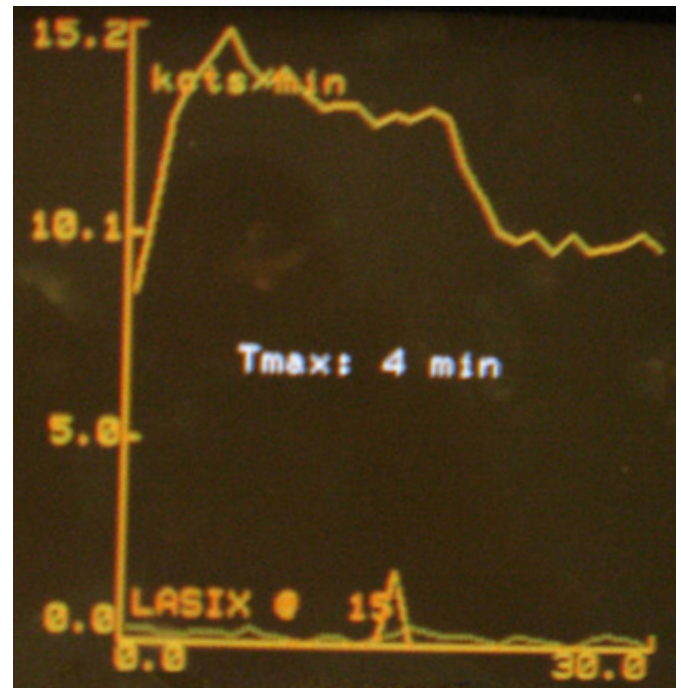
$\text{Tc}$ -DTPA renal scintigraphy with dynamic acquisition of sequential images showed an increase in the time of collecting of the tracer and a delay of excretion.
